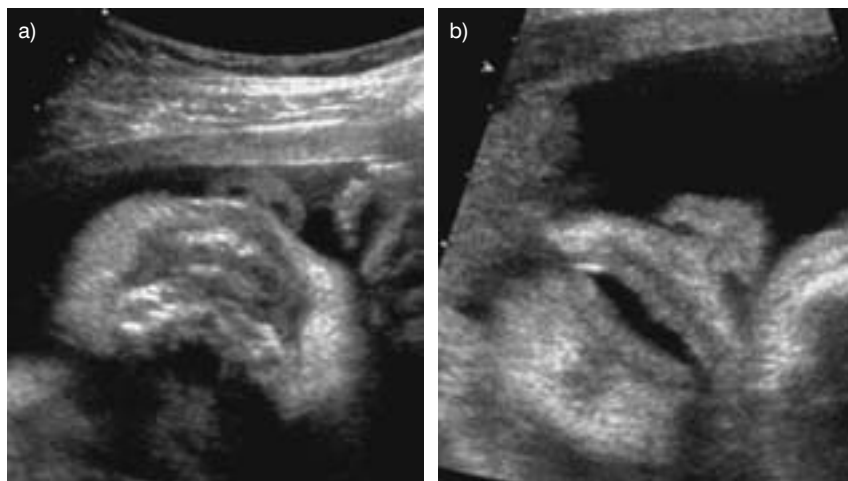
2D ultrasound depiction of the primary palate in coronal oblique section (a). Depiction of the lips is easier if they are opened (b)
